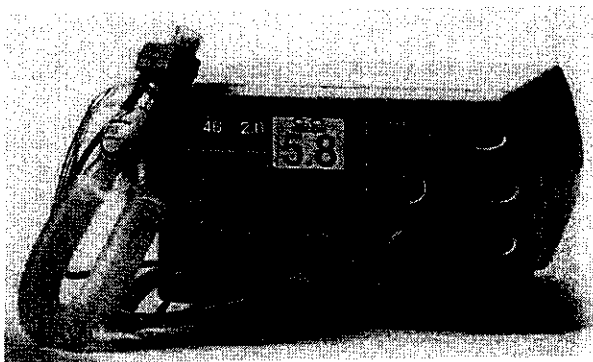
The NICO₂ system (Novamatrix Medical Systems, Inc, Wallingford, CT) measures cardiac output based on changes in end-tidal carbon dioxide after a brief period of rebreathing.
